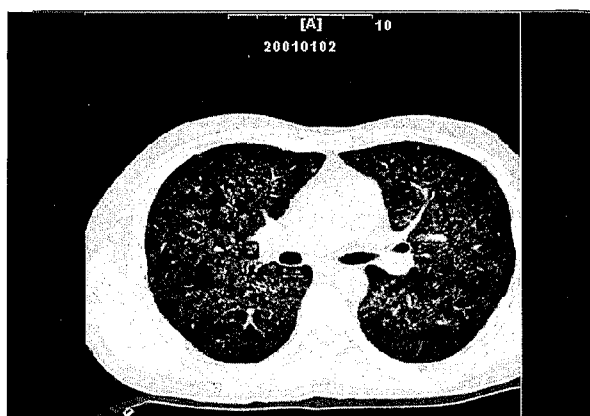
Chest CT (admission): diffuse reticulonodular infiltration.
